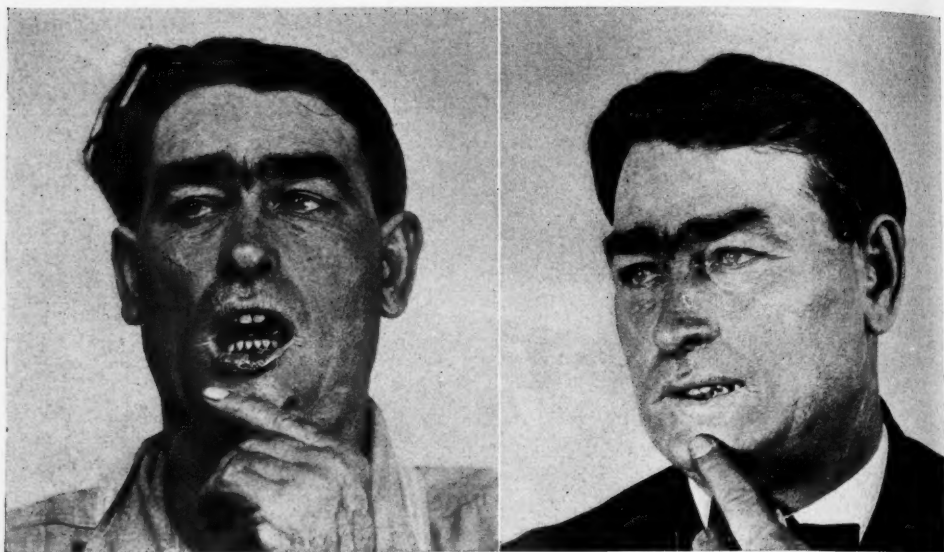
Truck driver, age 32. Was first seen August 29, 1922. Family history was negative. The lower lip had been mashed several times. In 1920 a warty growth appeared, continuing to grow until half of lip was involved. Base was indurated, edges everted, and center ulcerated (Fig. 7A, left), on right side of face—this also had been treated with a plaster. At time of his visit entire upper lip Clinical diagnosis was squamous cell carcinoma. Seven double erythema doses of X-rays through a cone one inch in diameter removed every trace of lesion (Fig. 7B, right). There had been no evidence of recurrence January 1, 1926.
